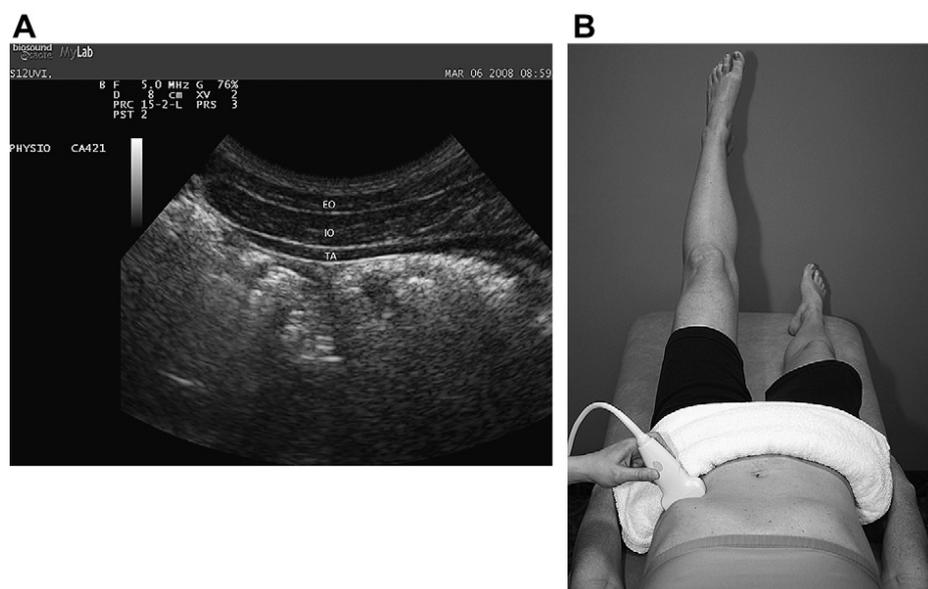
(A) An ultrasound imaging of the lateral abdominal wall muscles (EO = external oblique; IO = internal oblique; TrA – Transversus Abdominis) taken during a clinical USI study of the lateral abdominal wall muscles during an active straight leg raise test (B).
